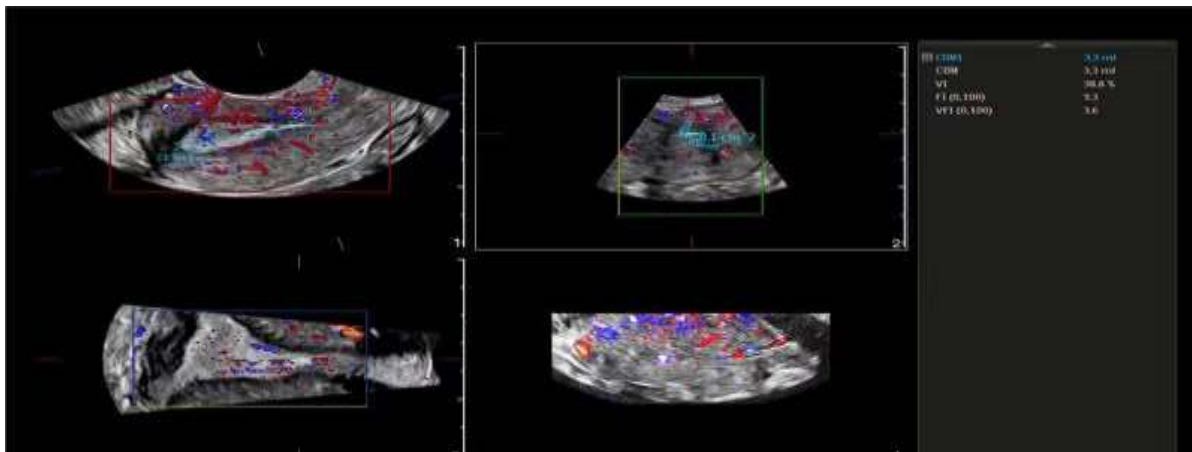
Using transvaginal three-dimensional ultrasonography to measure subendometrial blood flow parameters
